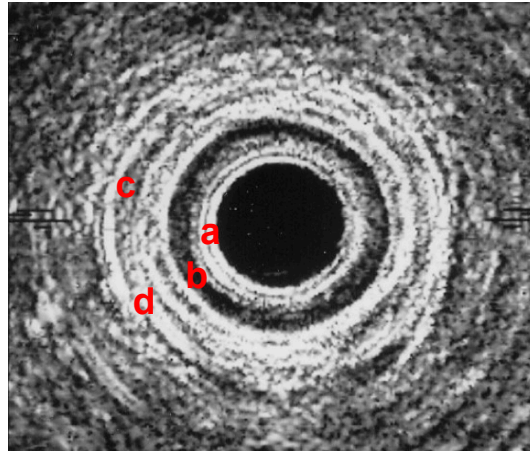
Normal structure of the anal canal. From internal to external, the separate layers are: (a) the submucosa, which appears as a highly hyperechoic (white) ring adjacent to the ultrasound probe, (b) the smooth muscle internal sphincter (IAS), which appears hypoechoic (black) and is approximately 2 mm thick, (c) the longitudinal muscle, which is a muscle band external to the IAS with similar echogenicity as the submucosa, and (d) the external sphincter (EAS), which appears as a modestly hyperechoic ring (Rottenberg and Williams, 2002), around 4-10 mm in thickness (Felt-Bersma and Cazemier, 2006).
